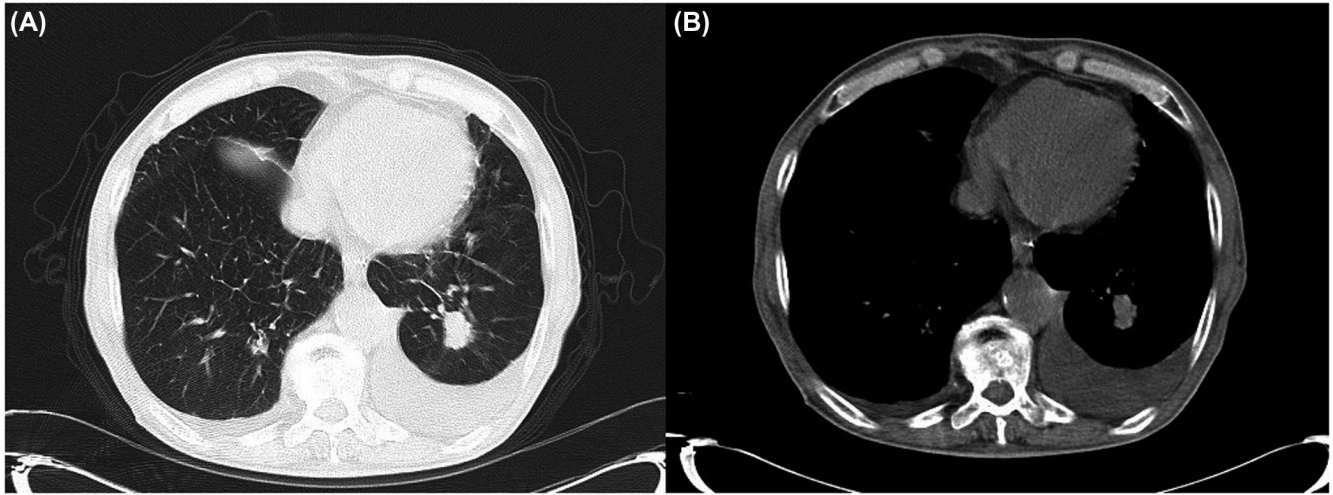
Chest CT of a 77-year-old male patient showing a solitary pulmonary nodule suspicious of malignancy and pleural effusion in the posterior segment of the left lung lower lobe in the parenchymal window (A) and the soft tissue window (B)
